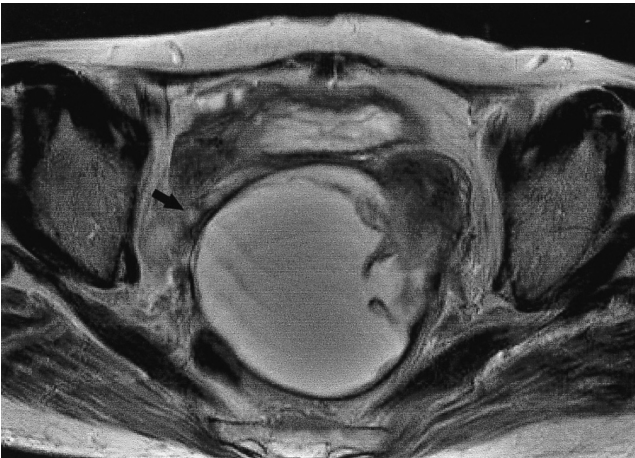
A 72-year-old postmenopausal woman with serous cystadenocarcinoma at left ovary. The right ovary (arrow) with multiple follicles is displaced and distorted by left ovarian mass on T2-weighted image (TR/TE=4000/132).
